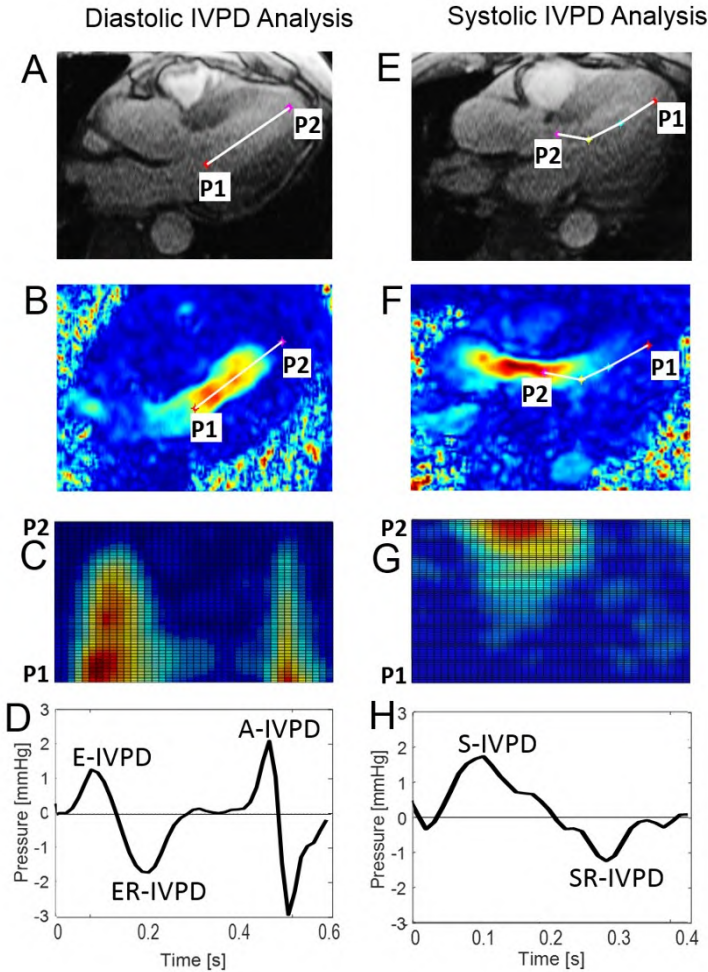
Graphical description of the phase-contrast MRI sequence processing to assess diastolic function (left column) and systolic function (right column). A) and E) Original magnitude images and B) and F) calculated velocity vectors images, showing the reference points selection, located at: Left) the mitral annulus (P1) and LV apex (P2); and Right) LV apex (P1) and aortic annulus (P2). C) and G) the pseudo CMM image, calculated from the 2D velocity vectors, was used as quality reference of the IVPD curves. Calculated IVPD curves (solid black line): D) during diastole, showing the (i) E-wave (E-IVPD), (ii) reversal E-wave (ER-IVPD) and (iii) A-wave (A-IVPD) pressure peaks, and H) during systole, showing the (i) S-wave (S-IVPD) and (ii) reversal S-wave (SR-IVPD) pressure peaks. C-D and G-H are aligned in time, respectively. Important to remark, the colour scale in B, C, F and G is a visual guidance for the user during the processing, and the linear (2 points) or the curvilinear (4 points) approximations could be selected by the user for diastolic and/or systolic analysis. Figure adapted from [1].
